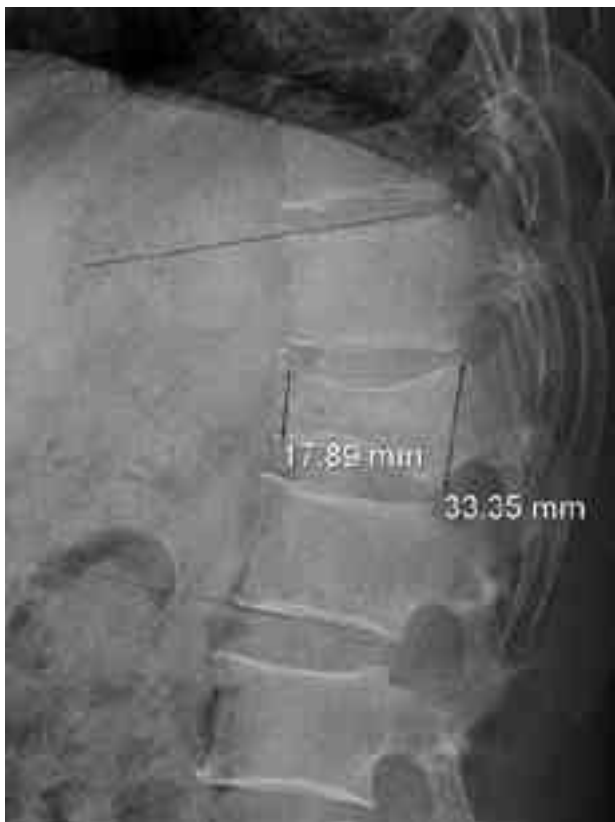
Initial simple x-ray lateral view of T12 compression fracture. Kyphotic angle is measured as 22.2 °, and wedge compression ratio is measured as 0.53.
